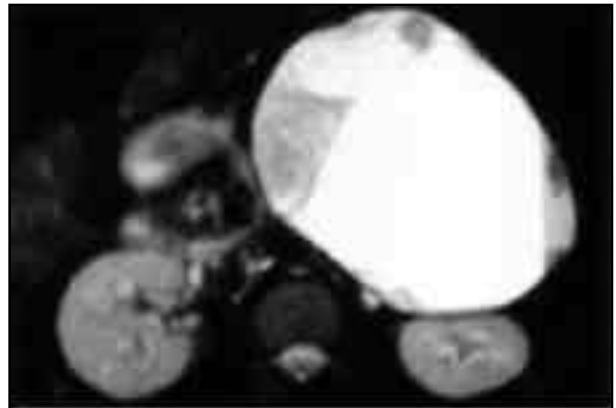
Ultrasound of SPEN, tail of pancreas, showing the large, well-encapsulated, predominantly cystic tumor with a frond of solid tumor in the right lower corner
